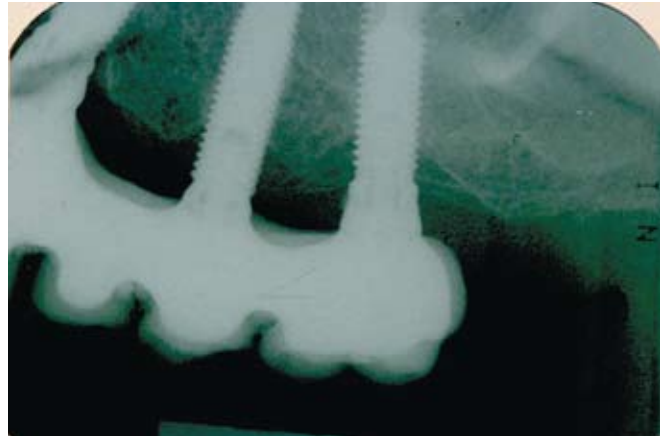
Clinical situation. Periapical x-ray at baseline evaluation. Note the vertical 2-wall bone defect in implants #25 and #26.
